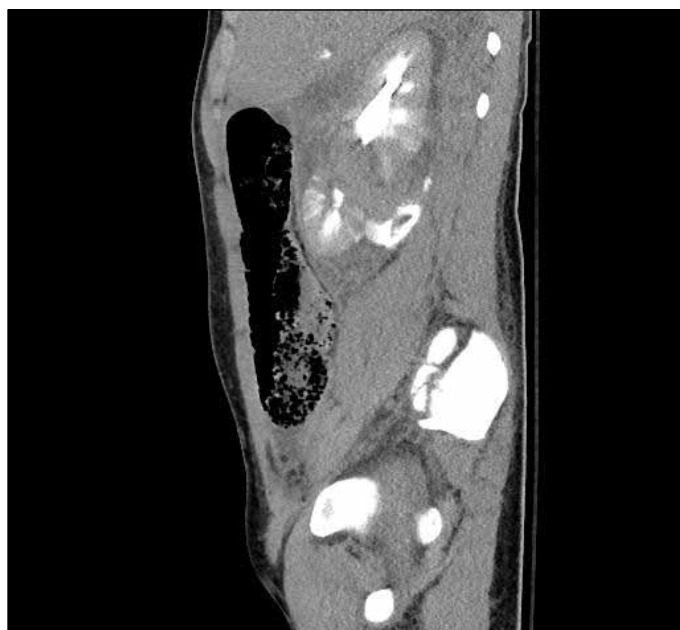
Computed tomography scan performed at presentation showing Grade IV renal injury.
